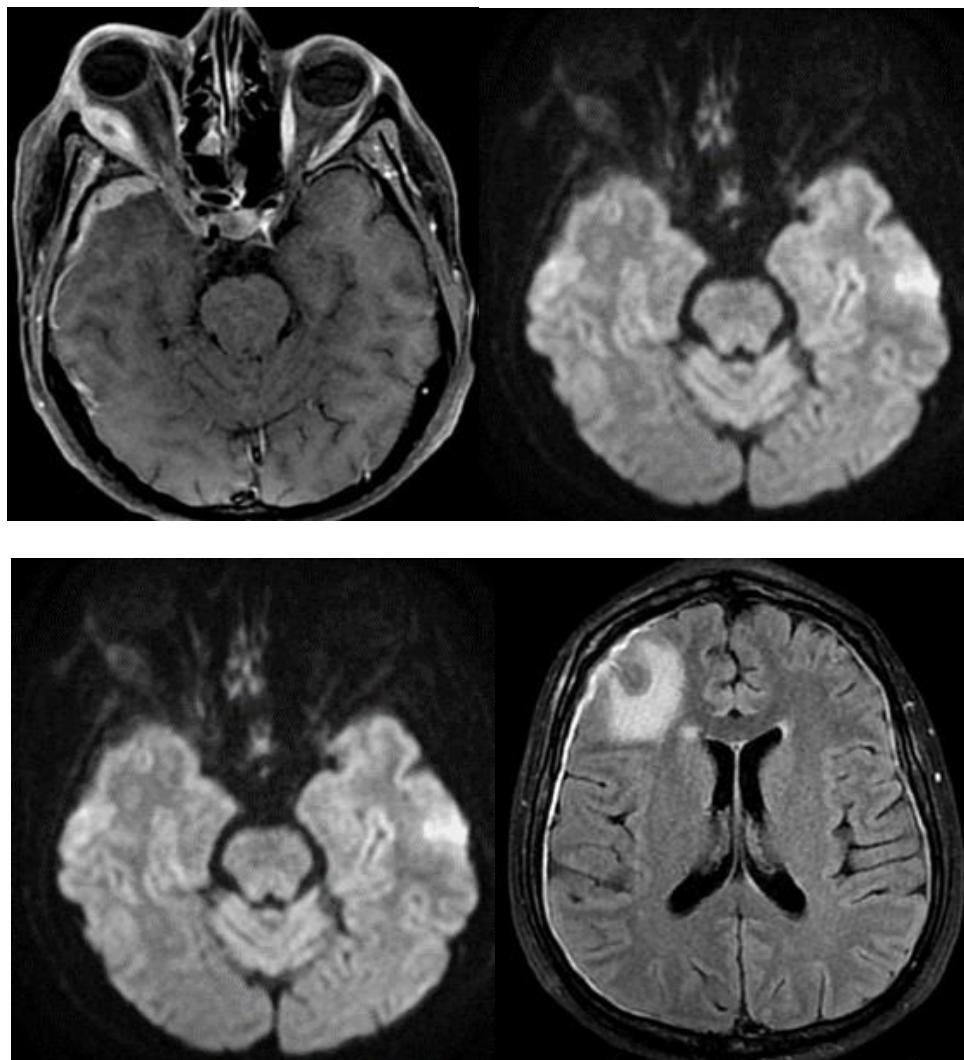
In contrast T1 axial images, mass lesion in the right lateral rectus muscle, dural thickening and contrast involvement in the adjacent intracranial space and contrasting in subcutaneous plans are observed. 1b. Diffusion b 1000 MR images do not show diffusion limitation in the mass in the lateral rectus. 1c. In contrast axial FLAIR (c) and T1 weighted images (d), bilateral dural involvement as well as parenchymal extension and cerebral edema are seen to develop in the right frontal adjacent to dural involvement. 1d. In contrast axial FLAIR (c) and T1 weighted images (d), bilateral dural involvement as well as parenchymal extension and cerebral edema are seen to develop in the right frontal adjacent to dural involvement.
